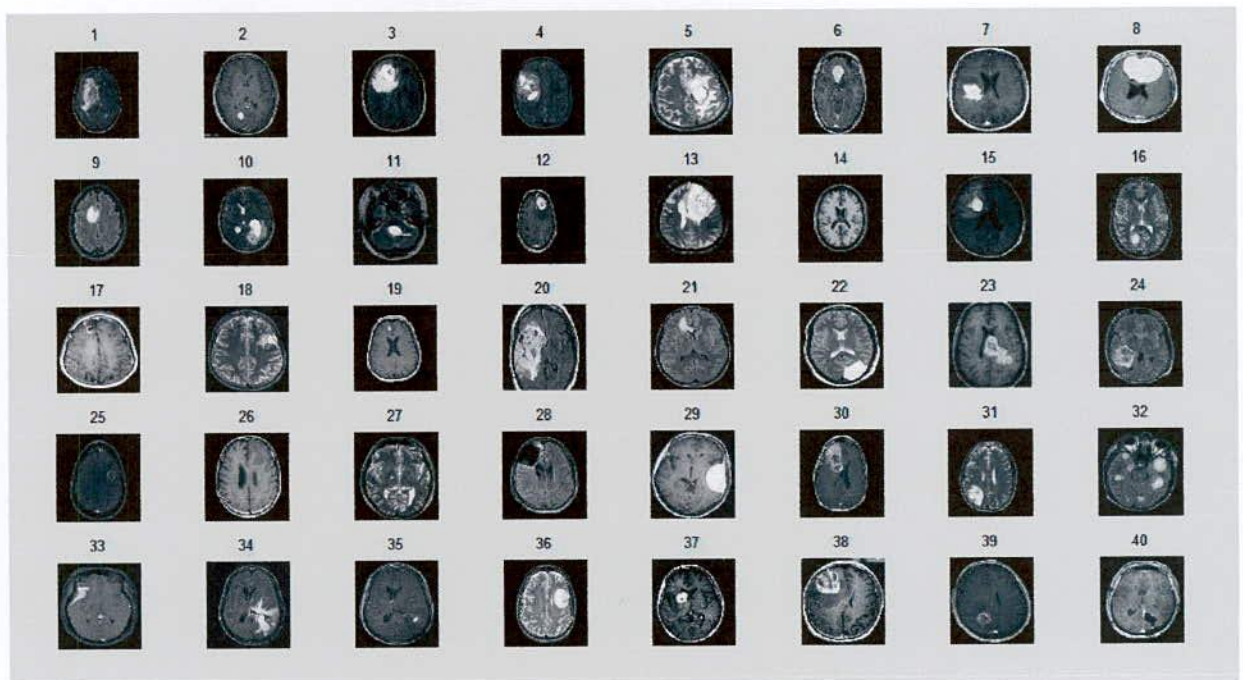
The database of 40 brain tumor MRI image
